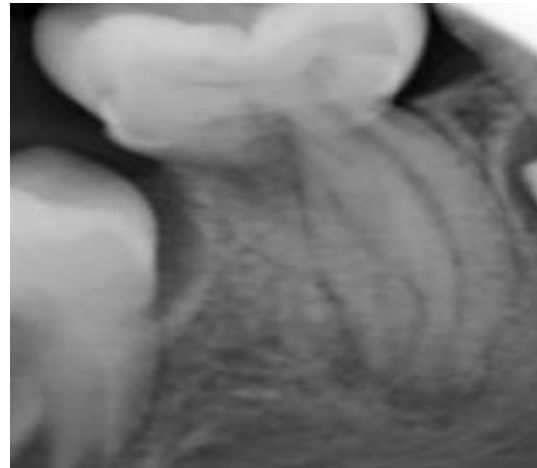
Periapical X-ray of tooth number 46.
